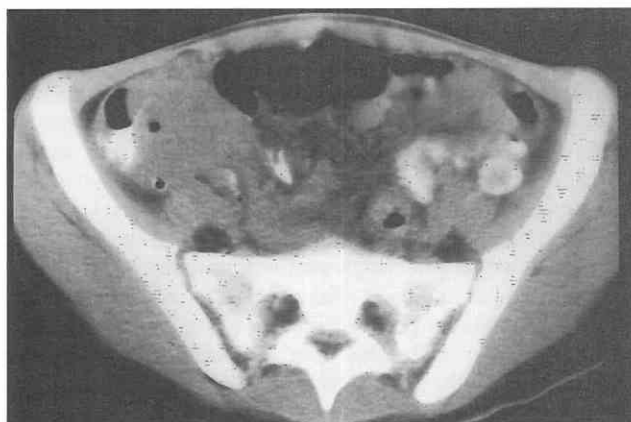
Crohn's disease complicated by perforation and phlegmon formation. CT scan through the upper pelvis in a patient with Crohn's disease demonstrates a phlegmon in the right iliac fossa.
